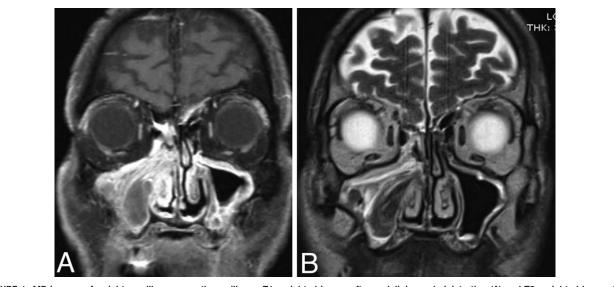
MR images of a right maxillary oncocytic papilloma. T1-weighted image after gadolinium administration (A) and T2-weighted image (B) on the coronal plane.
